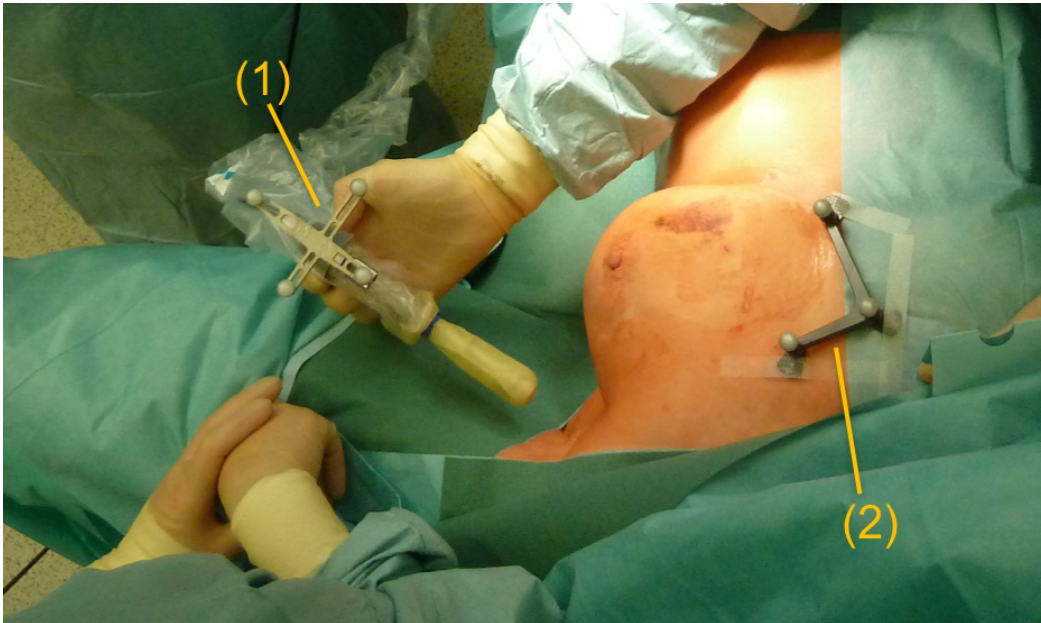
Tracking targets of the Freehand SPECT system. (1) Sterile probe target attached to the gamma probe in sterile covering for tracking the position and orientation of the probe throughout the surgery. (2) Sterile patient target serving as a reference coordinate system for displaying the 3D Freehand SPECT reconstruction relative to the patient.
